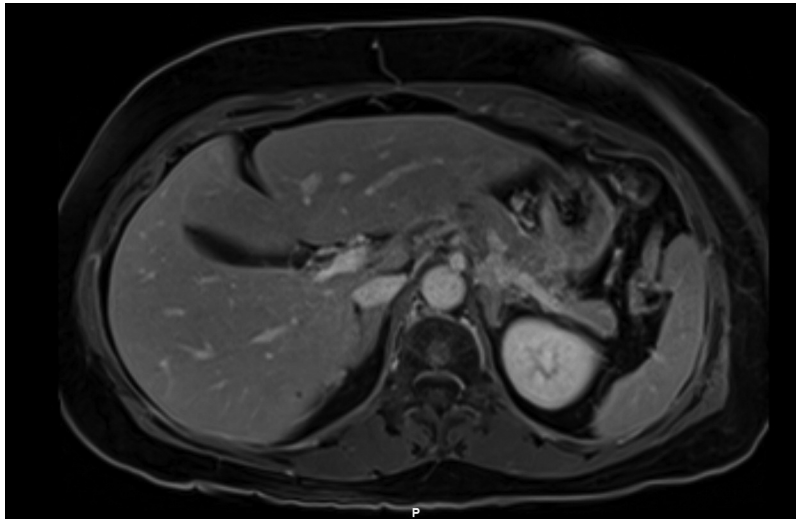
Pre-operative MRI of the abdomen with and without IV contrast. Ill-defined, infiltrative soft tissue in the tail of the pancreas and left adrenal gland, measuring 1.5×1.5 cm (yellow arrow).
